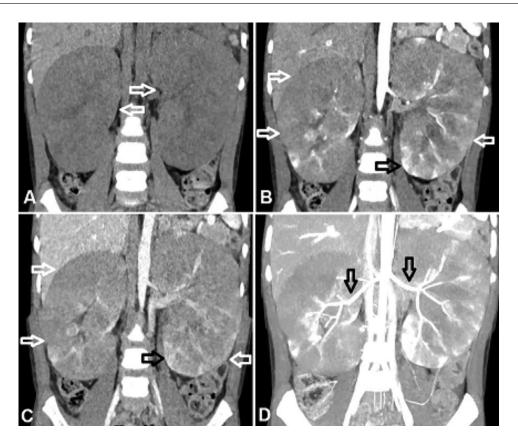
Abdominal computed tomography (CT) scans before treatment. (A) Noncontrast CT scans showed bilateral, symmetrical enlargement of both kidneys (arrows). The arterial phase (B) and venous phase (C) showed multiple hypoenhancing areas throughout both kidneys (white arrows), although some areas of the renal parenchyma still enhanced normally (black arrows). (D) Maximum intensity projection (MIP) showed that neither renal artery was occluded (black arrows).
